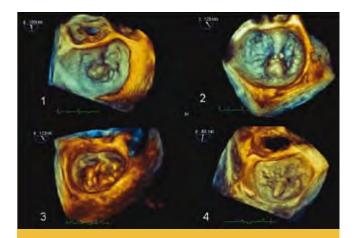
Surgical view of the mitral valve on transoesophageal echocardiography, showing 4 examples of P2 segment prolapse. Image 1: prolapse of the lateral portion of P2 and part of P1, with chordal rupture in that region. Image 2: central portion of P2 is flail with chordal rupture. The regurgitant jet tracks over A2 where a deep ridge is visible. Image 3: A lateral portion of P2 prolapse with chordal rupture. There is a deep "cleft" in the P2 segment, extending back to the annulus, on the right of the prolapse. Image 4: Central P2 segment prolapse with several points of chordal rupture.
